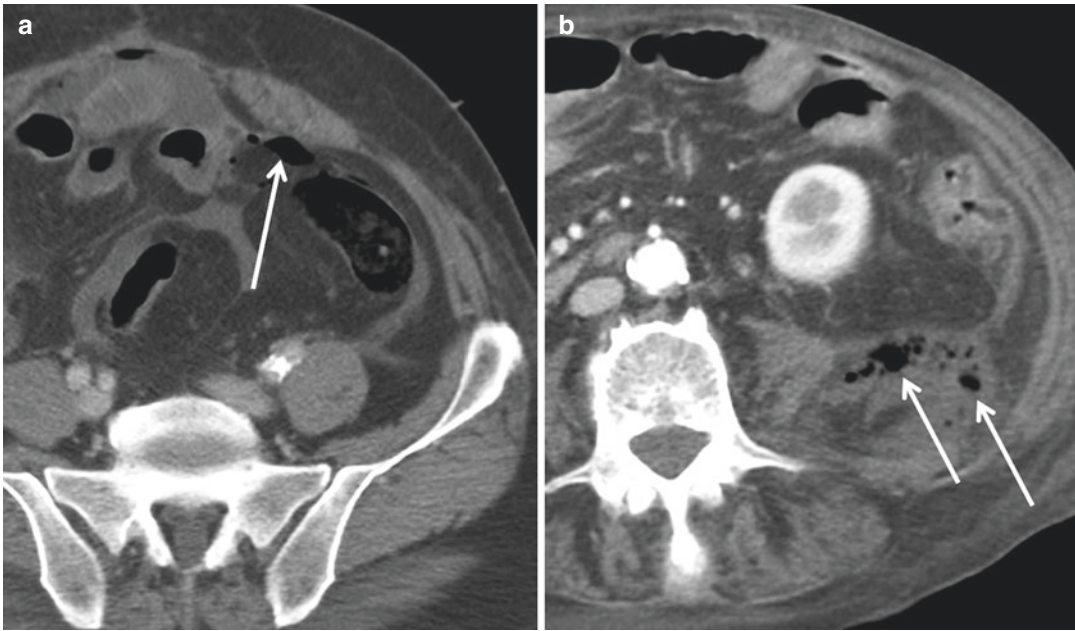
Axial CT contrast-enhanced scans show air foci trapped in the mesentery (*arrow in a*). Free air in the retroperitoneum (*arrows in b*)
